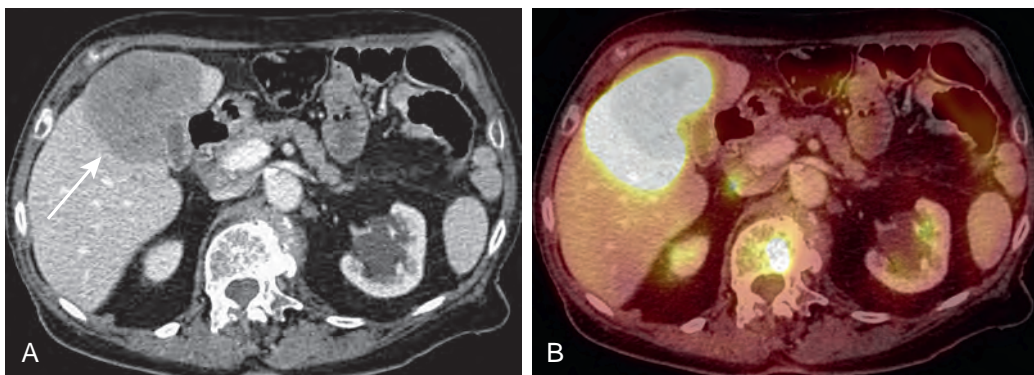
Hepatic lymphoma. A. Contrast-enhanced CT demonstrates a solitary, large, low-attenuation lesion in the liver (arrow) adjacent to the gallbladder. B. PET/CT demonstrates the increased FDG avidity of the lesion. Percutaneous biopsy confirmed lymphoma.
